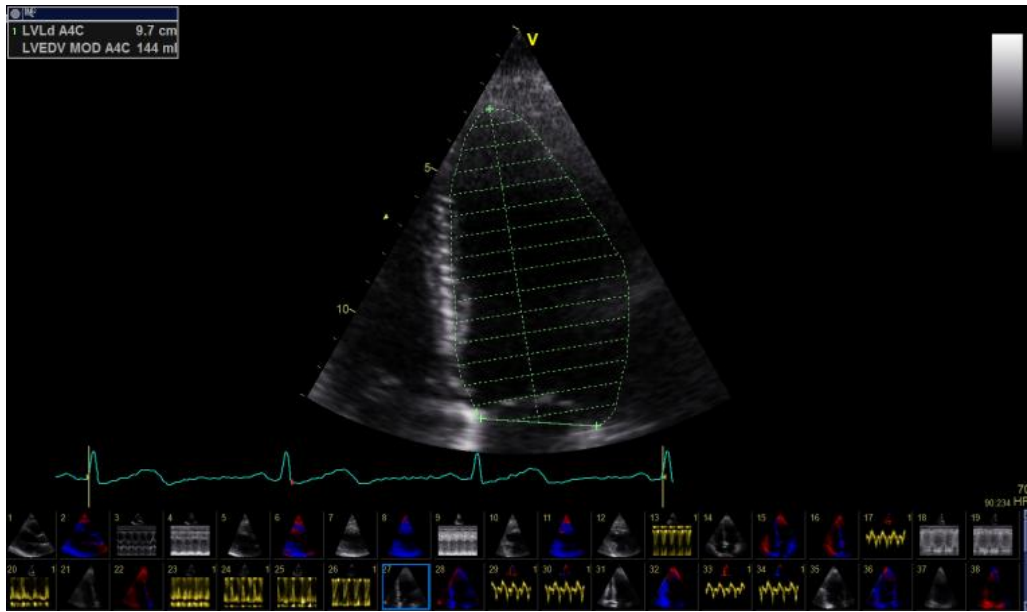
Estimation of left ventricular volumes by the Simpson's Bi-plane Method. Picture first: From the 2D apical four chamber view, the ventricular endocardium of left ventricle was traced at end diastole to determine the left ventricular end diastolic volume. Picture second: From the 2D apical four chamber view, the endocardium was traced at end systole to determine the end systolic volume.
